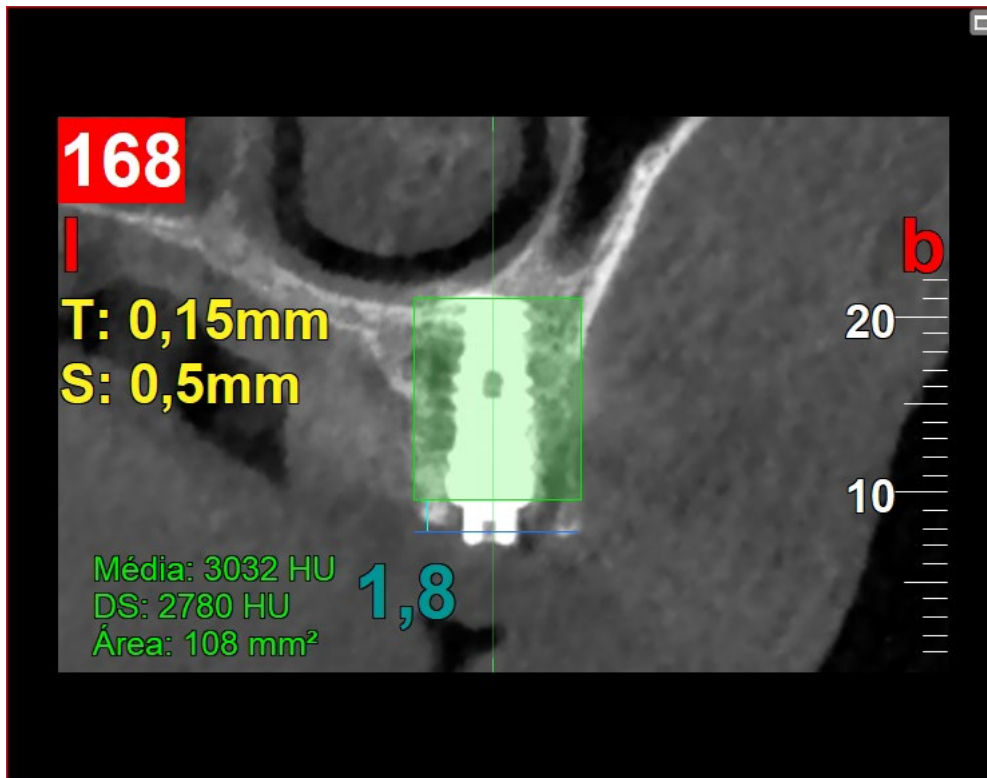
Immediate post-operative CBCT considering bone height and density.
